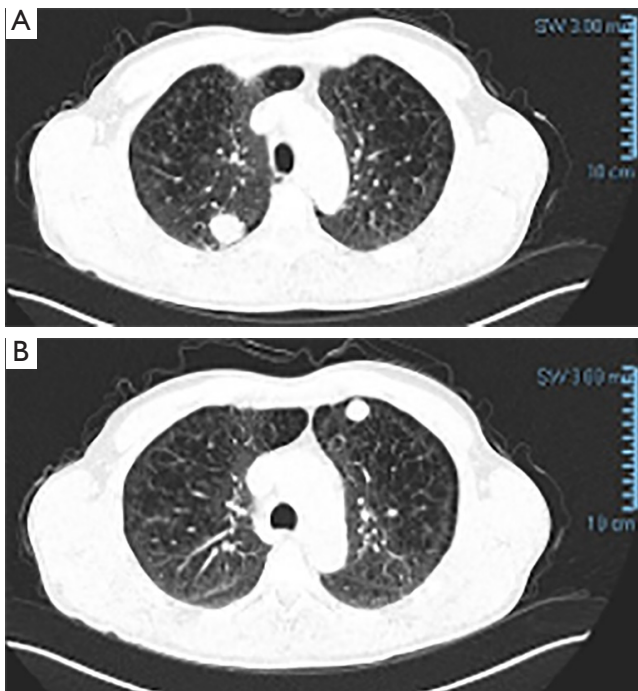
CT scan showing two lesions located the right upper lobe (A) and left upper lobe S3 (B).
